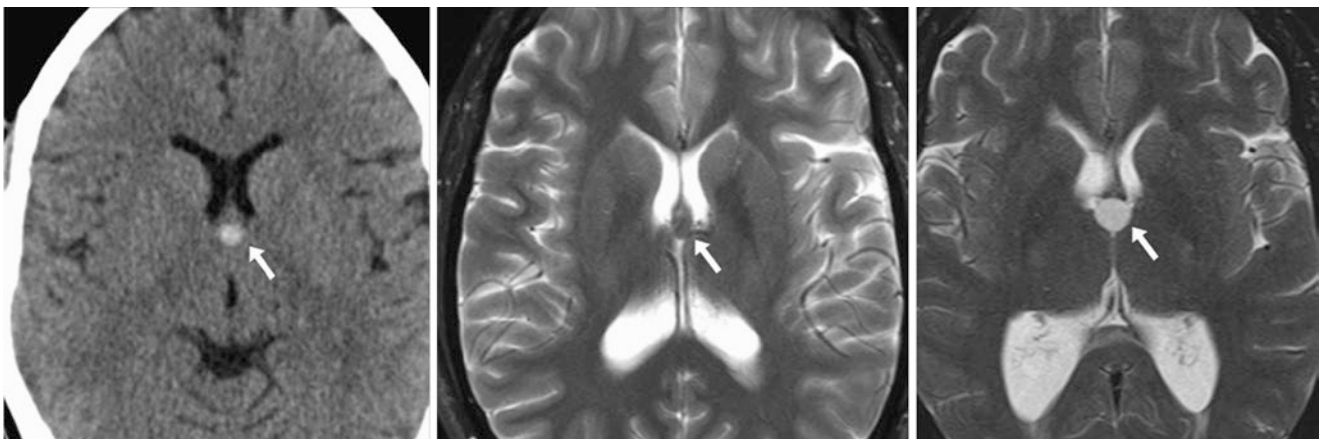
Comparison case of colloid cyst: a 25-year-old patient had a hyperdense lesion (noncalcified) at the midline within the anterior third ventricle on NECT (left) and on T2WI MRI (middle) without hydrocephalus. The patient returned 5 years later with neurologic symptoms, as the cyst had enlarged on T2WI (right) with enlarging lateral ventricles. Note the characteristic location
